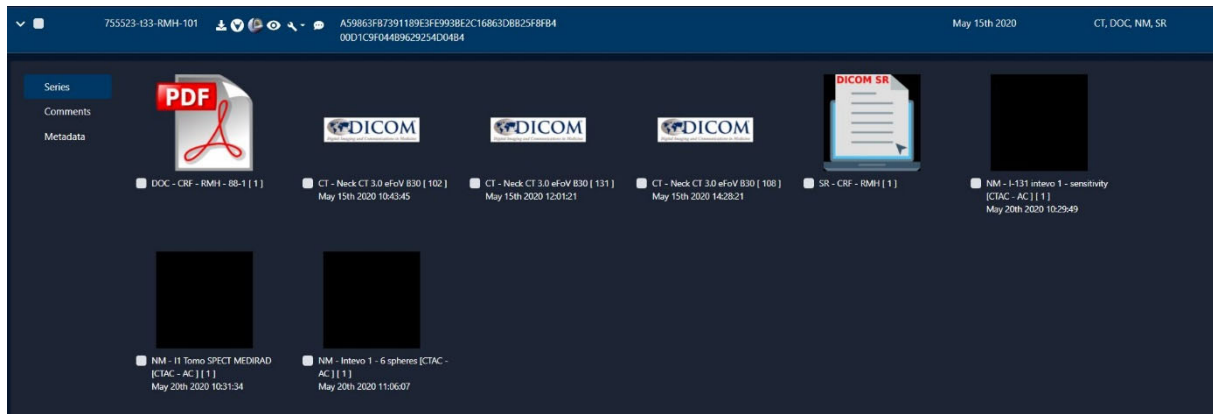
Example of data for a patient which includes 3D images of the I-131 distribution scan (SPECT), CT, e-CRF and structured report (SR).
